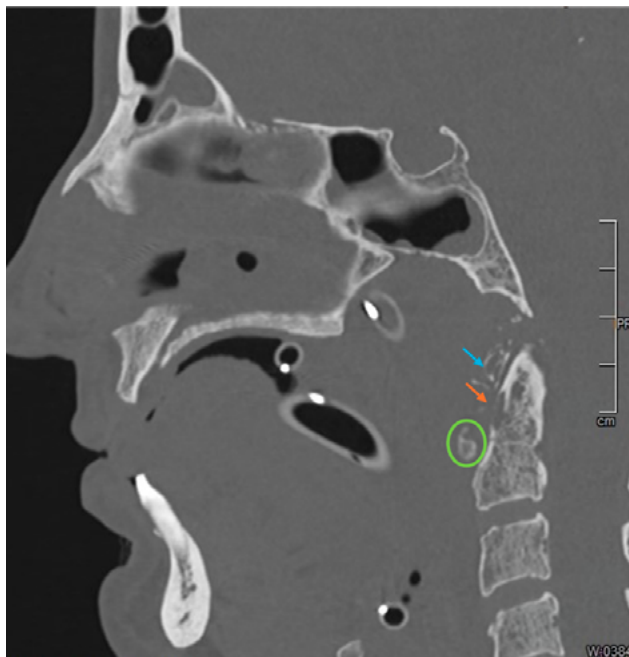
Head and neck CT scan - sagittal view: foreign body (green circle) and bone erosion of the atlas' anterior arch (blue arrow) and axis' odontoid process (orange arrow)
